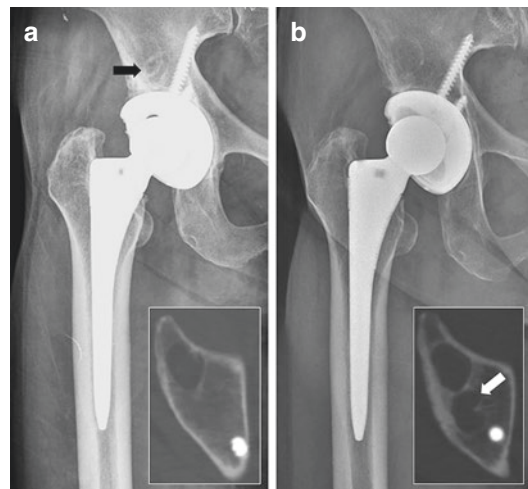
(a) Radiograph and CT scan taken at 2 years after THA using HXLPE show subchondral cyst (black arrow) at the ilium. (b) Radiograph and CT scan taken at 14 postoperative years. Osteolysis is not definite on radiograph but is seen on CT scan (white arrow)
